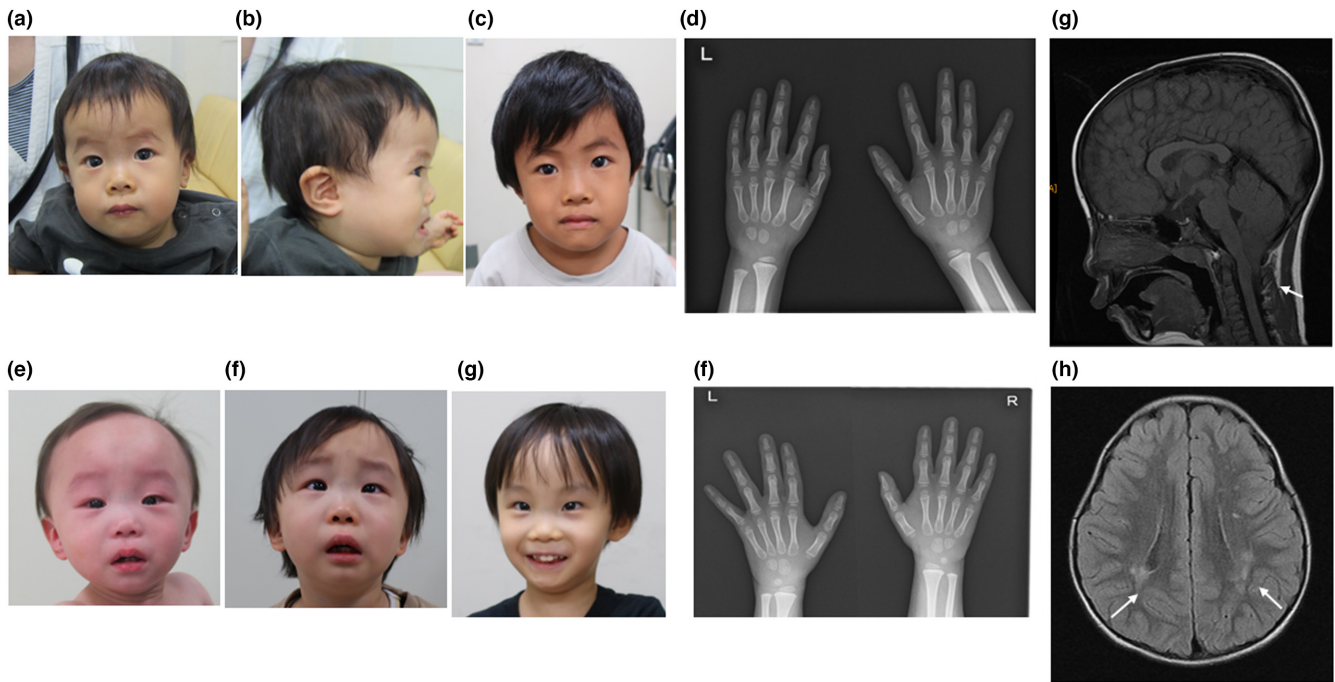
Photographs of individuals with RAUST. Note that craniofacial dysmorphic features including relative macrocephaly, mild triangular face, broad forehead, high anterior hairline, broad arched and laterally sparse eyebrows, full cheeks, thin and elevated nasal bridge, smooth short philtrum, prominent cupid bow, thick everted lower lip vermilion, and protruding ears. Both individuals do not have the ‘Greek warrior helmet’ facial features of WHS. Photographs of Individual 1 (a, b—1 year and 6 months, c—5 years and 8 months) and Individual 2 (e—1 year and 2 months, f—4 years and 4 months; g—4 years and 11 months). X-ray imagings of bilateral carpal bones of individual 1 (d—5 years and 8 months) and individual 2 (f—5 years). Bone age is delayed by about 2 years in both individuals. Brain MRI findings of individual 2 (g—Chiari malformation type 1, h—bilateral T2WI high signal in the cerebral white matter).
